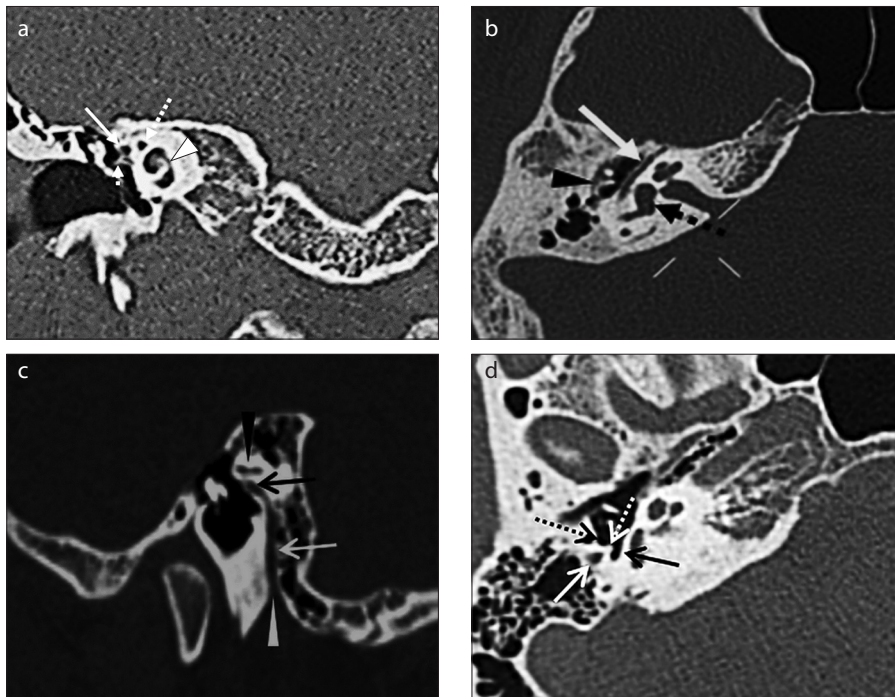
a–d. Anatomy of the right FN on axial (b, d), coronal (a), and sagittal (c) HRCT. The tympanic segment of FN (a and b, white arrow) is related to the lateral semicircular canal superiorly, labyrinthine segment of FN and cochlea medially (a, dotted white arrow and white arrowhead, respectively), the cochleariform process (a, short arrow) and the oval window inferiorly, the vestibule medially (b, black dotted arrow), and the incus laterally (b, black arrowhead). The posterior genu (c, black arrow) is related to the lateral semicircular canal superiorly (c, black arrowhead), fossa incudis superolaterally and the ponticulus superomedially. The intramastoid segment of FN (c and d, white arrow) is related to the facial recess anterolaterally (d, black dotted arrow), the pyramidal eminence anteriorly and the sinus tympani anteromedially (d, dotted white arrow and black arrow, respectively).
